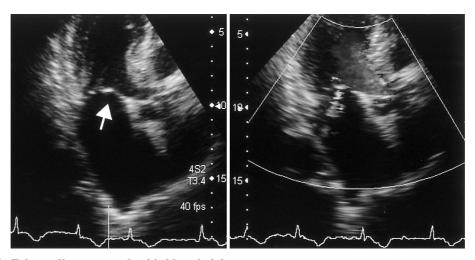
Echocardiograms on the third hospital day
